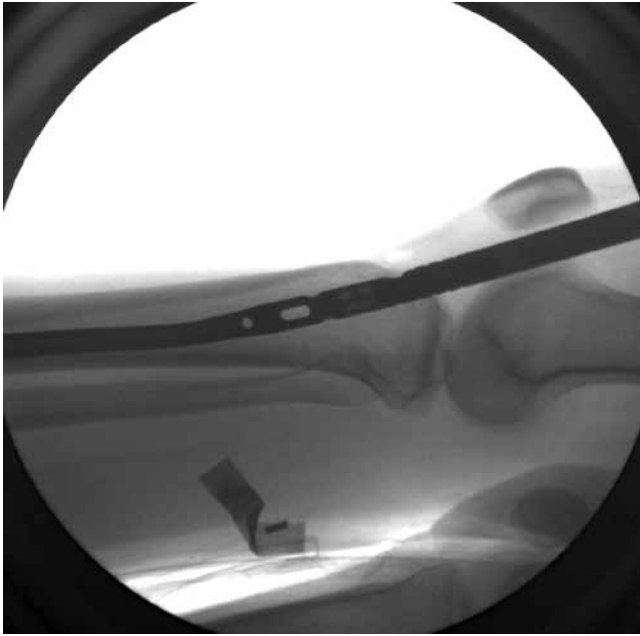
Lateral radiograph showing tibial nail insertion using suprapatellar guide.
